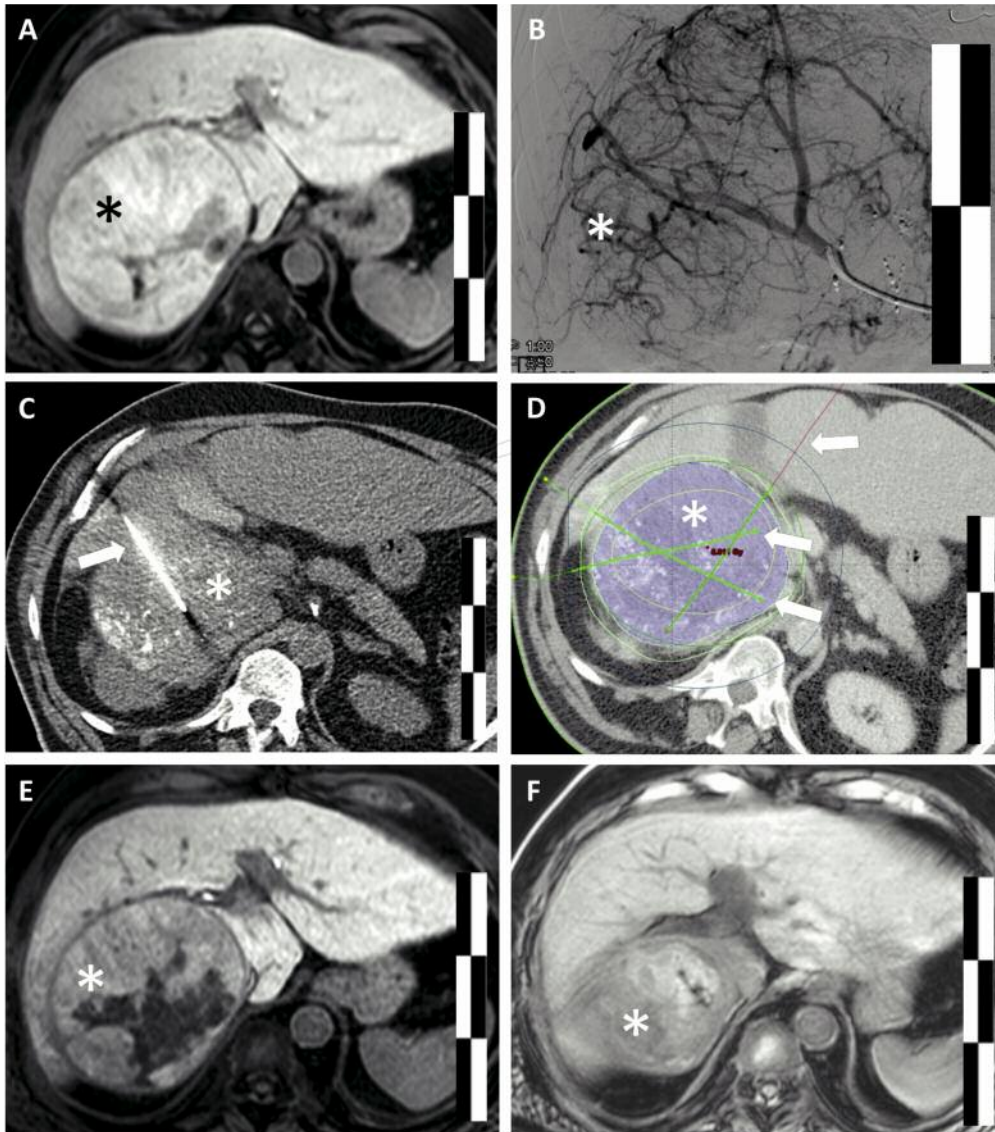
Treatment process of a patient treated with the combination of bland embolization and CT-HDRBT. (A) Shows the pretreatment MRI imaging of the tumor. (B) Shows the hypervascularisation of the tumor on DSA before Chemoembolization. The good delineation of the tumor on native CT imaging due to the Lipiodol deposition is shown in C. (D) Depicts the dose planning of the CT-HDRBT after placement of the catheters. (E) and (F) show the shrinkage and necrosis inside the tumor on follow-up imaging after 3 and 15 months, respectively. *Indicates the tumor while the arrows point to the CT-HDRBT catheters. Scale bars: 5/10 cm (B) and 5/10/15 cm (A, C-F).
